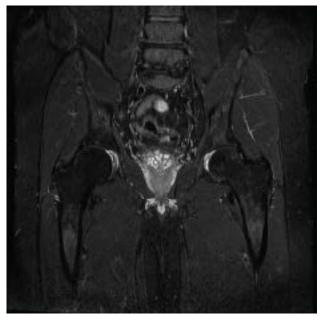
Post HBOT MRI Scan. MRI with avascular necrosis protocol including coronal T1 and STIR of bilateral hips. Axial T1 axial T2 fat sat and sagittal T2 hips were performed with comparison to the previous MRI. Examination demonstrates normal bone signal of the femoral heads bilaterally on coronal T1 and STIR sequences which demonstrates no evidence of transient osteoporosis, avascular necrosis or any signal abnormality.
